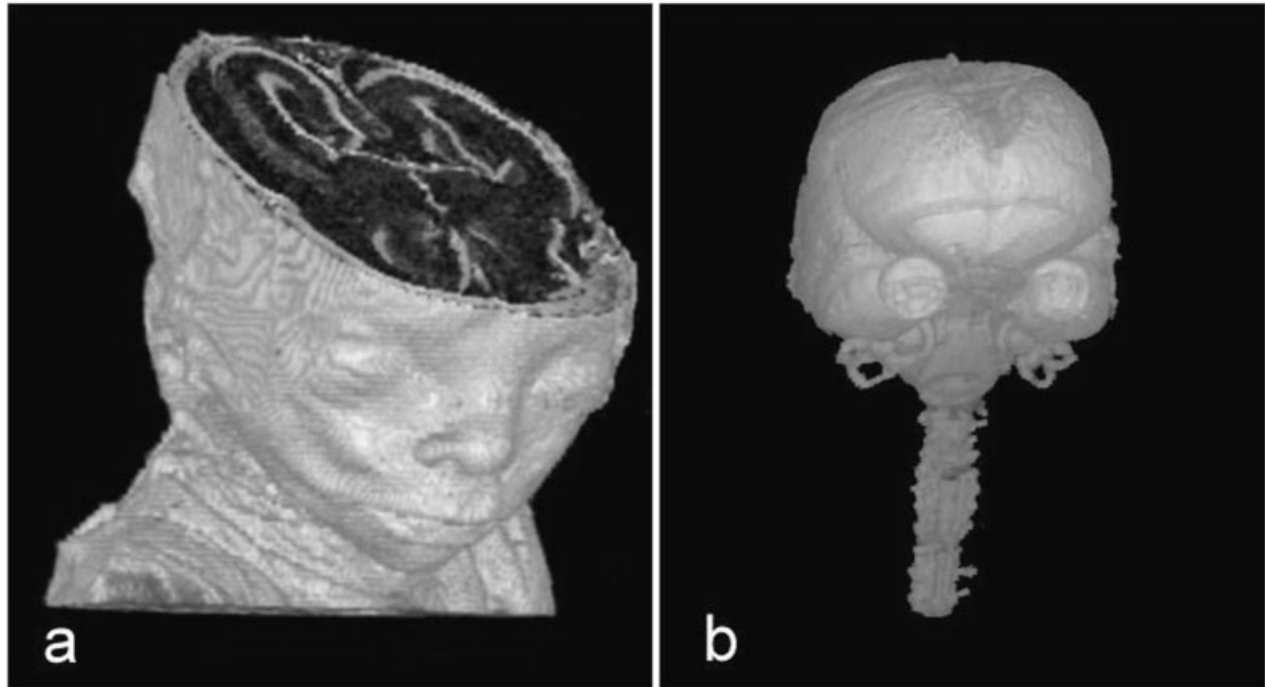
Volume rendered 3-D images based on the high-resolution MRI dataset of the 25 wk-old fetus shown in Figure 5 c. (a) Three-quarter frontal view, with the highest opacity assigned to the skin and the top of the head removed to demonstrate the brain morphology. (b) Lateral view, with the skin made transparent to demonstrate the outline of the brain, spinal cord, the inner ears and eyes.
